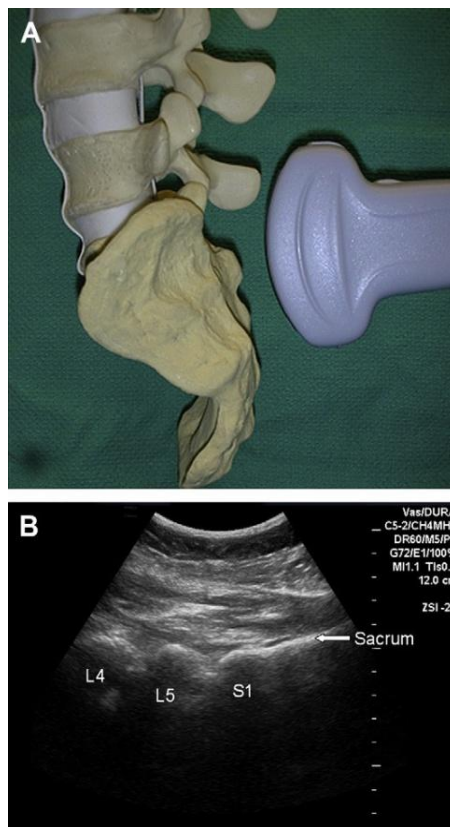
Identification of intervertebral space with ultrasound
